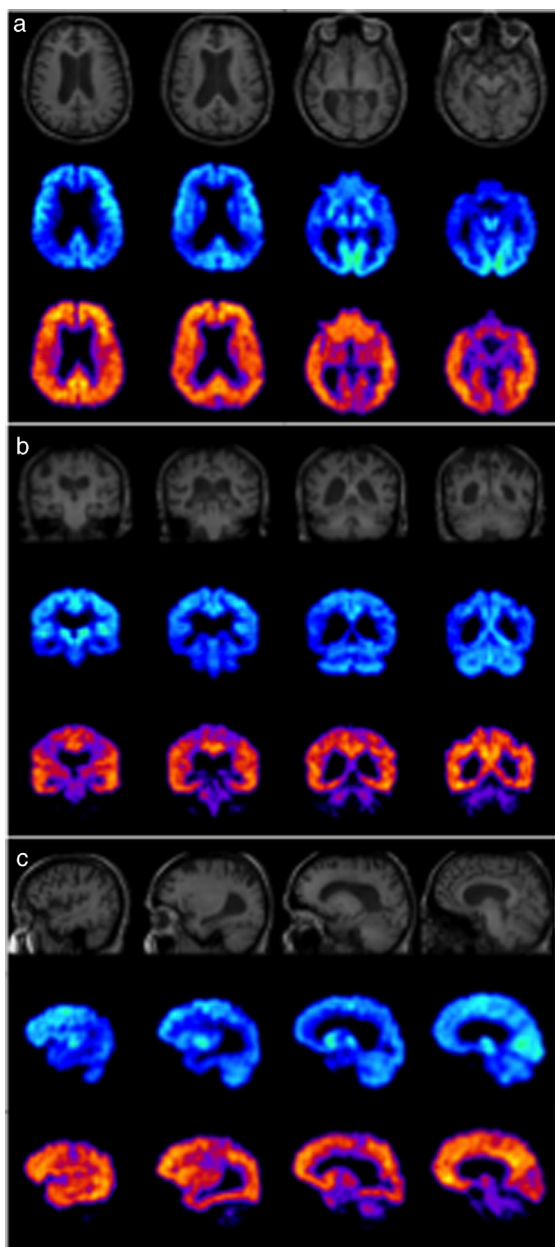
MRI (top), FDG-PET (middle), and PiB-PET (bottom) images of a typical AD case in axial (a), coronal (b) and sagittal (c) planes showing hypometabolism in parietal and temporal lobes in FDG-PET and extensive cortical amyloid deposition in PiB-PET.
